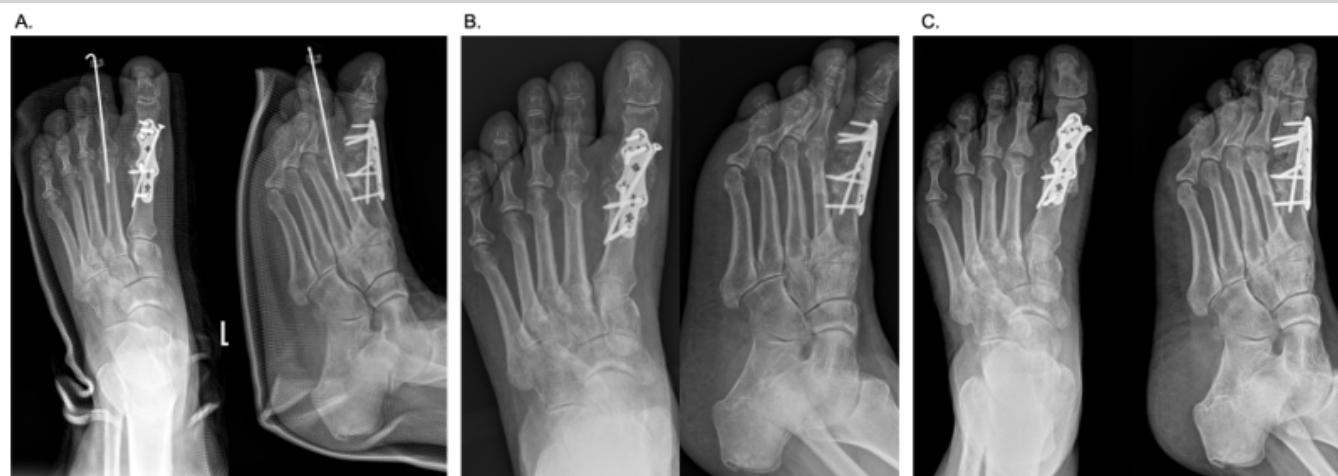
Revision arthrodesis. Serial post-operative anteroposterior and lateral radiographs, immediate post-operative; 3-month post-operative and 6-month post-operative radiographs demonstrating maintenance of alignment and progressive graft incorporation.
